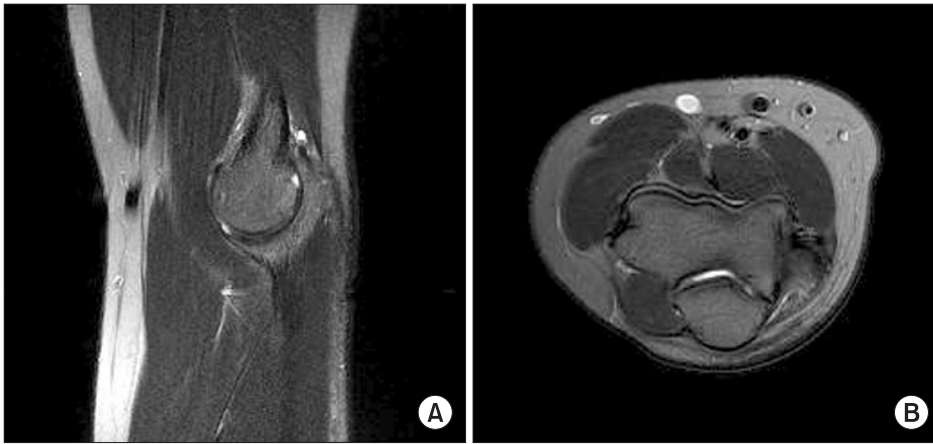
MRI showed formation of granulation tissue and fibrocartilage at operation site of osteochondritis dissecans of trochlea. (A) Axial. (B) Sagittal view.
